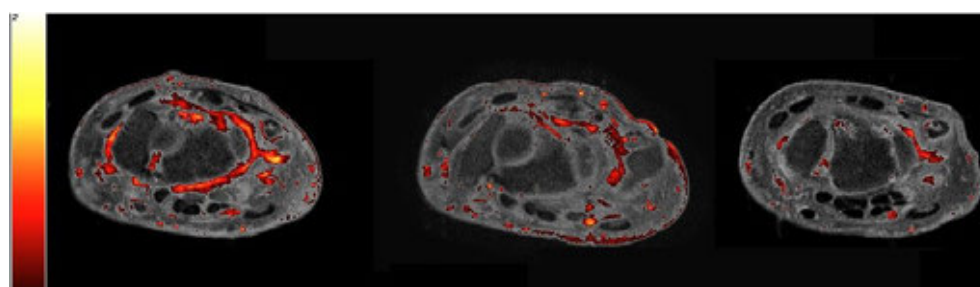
MRI scans and Norml maps superimposed on MRIs for a PsA patient imaged at baseline, Month 3 and 6.
